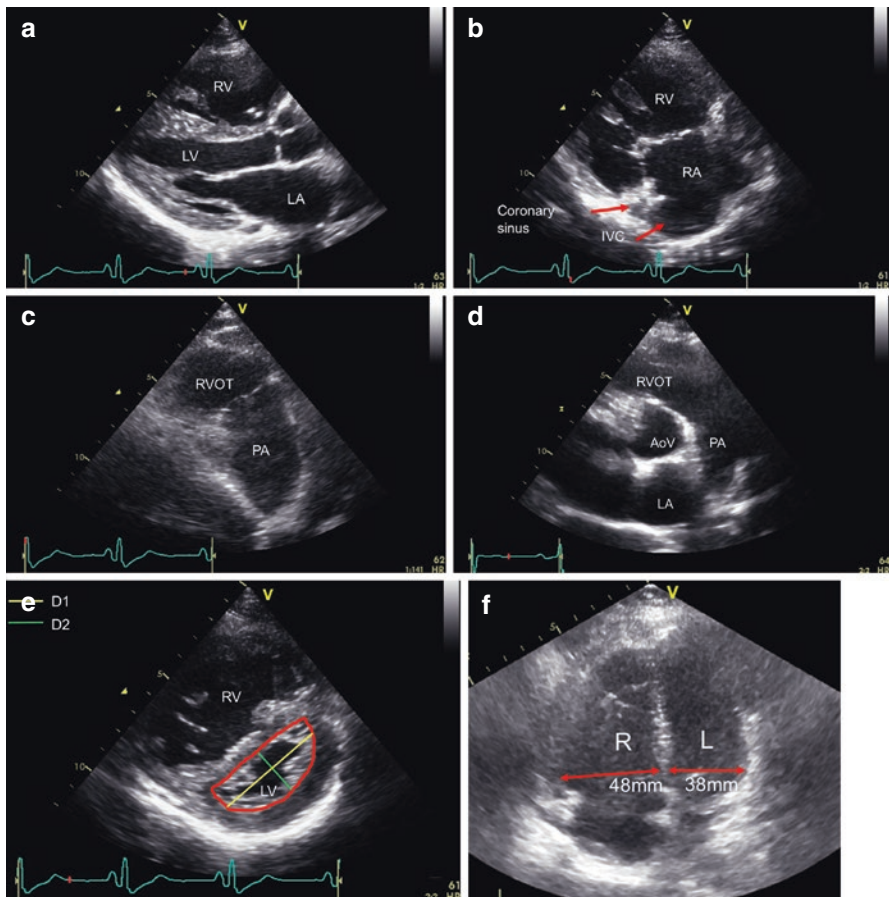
(a) Parasternal long axis view. (b) Parasternal long axis view of the right ventricle. (c) Parasternal long axis view of pulmonary artery and right ventricle outflow tract. (d) Parasternal short axis view at the level of the aortic valve. (e) Parasternal short axis view at the level of the papillary muscles. (f) Apical 4-chamber view
